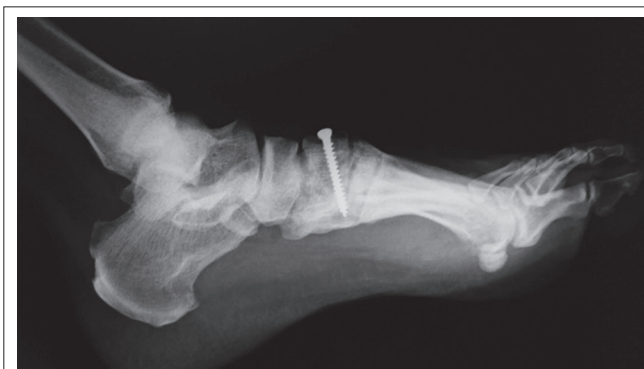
Follow-up radiograph at 1 year.
